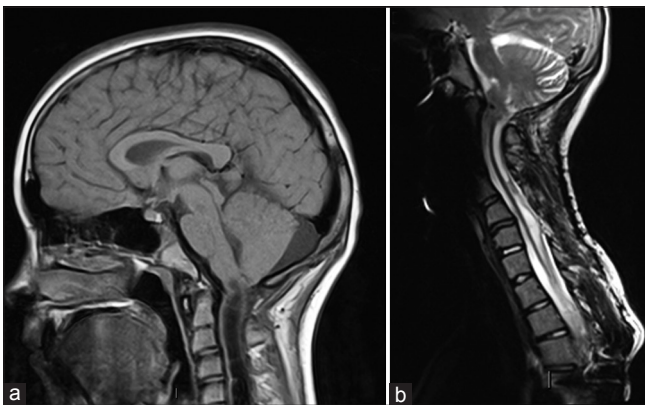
Preoperative MRI (a) at onset of neurological symptoms shows herniation of the cerebellar tonsils and a large syringomyelia which extended along the whole of the cervical and into the upper thoracic spine. Repeat MRI (b) after neurosurgical decompression and placement of a syringopleural shunt shows the syrinx to have markedly reduced and no pressure on the cerebellum at the foramen magnum
